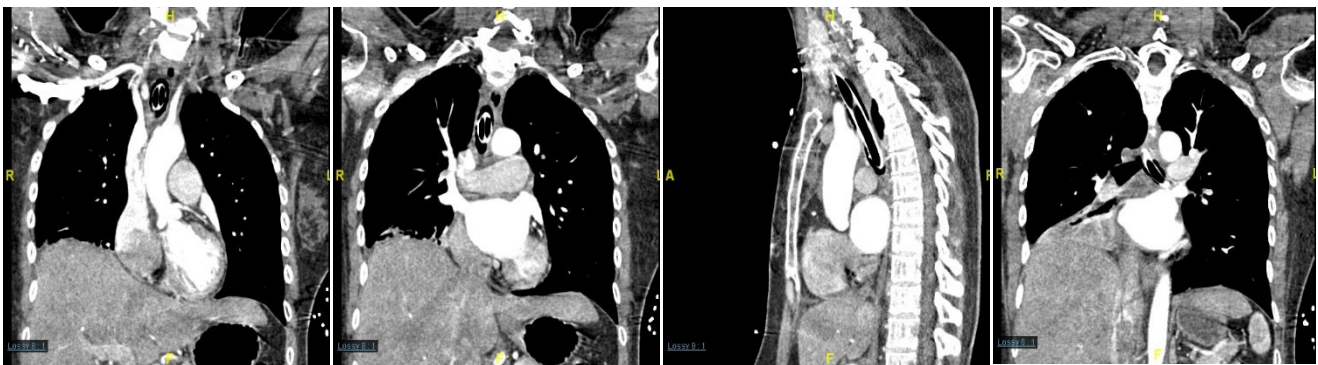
Computed tomography pulmonary angiography (CTPA) scan showing a mass over the anterior segment of the right lower lobe
